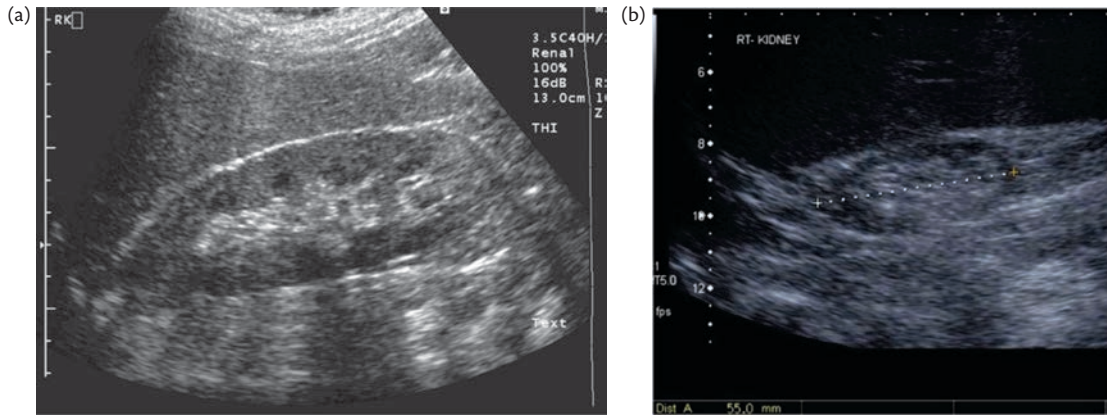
(a) Normal longitudinal ultrasound scan of right kidney. Notice the echogenic renal sinus fat, the dark evenly spaced pyramids and the even cortical echogenicity (a little darker than the adjacent liver). (b) Atrophic right kidney, 5.5 cm long. Note reduction in cortical thickness and the cortex is brighter than the adjacent liver.
